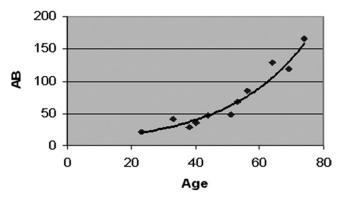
Relationship of AB with age. An exponential relationship of AB (units of SUV per milliliter) with age is shown. (Reprinted with permission.⁶²)
